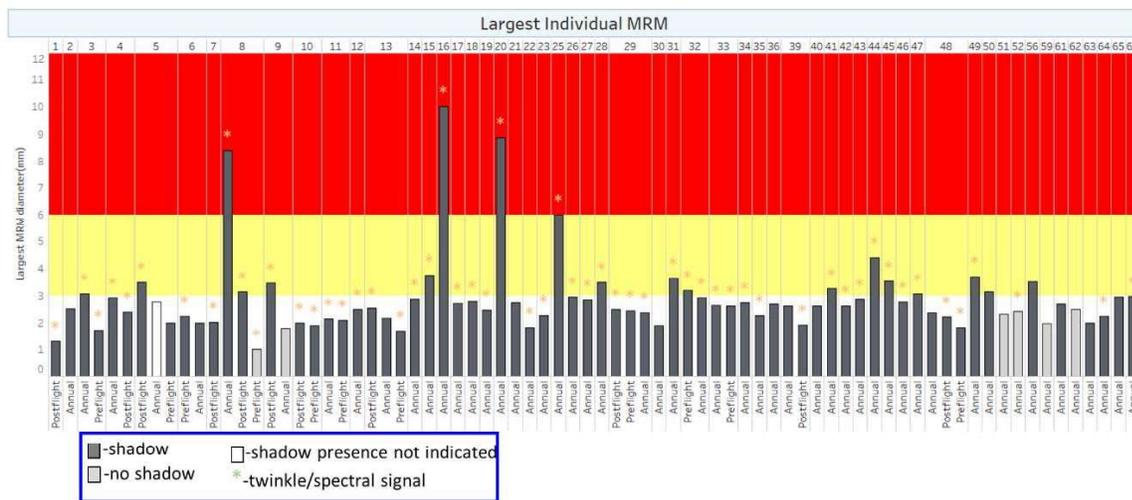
LSAH data on the size, location, and measurements of mineralized renal material in US astronauts (66). Different parameters of ultrasound indicators of MRM presence are shadow and twinkle/spectral signal.
